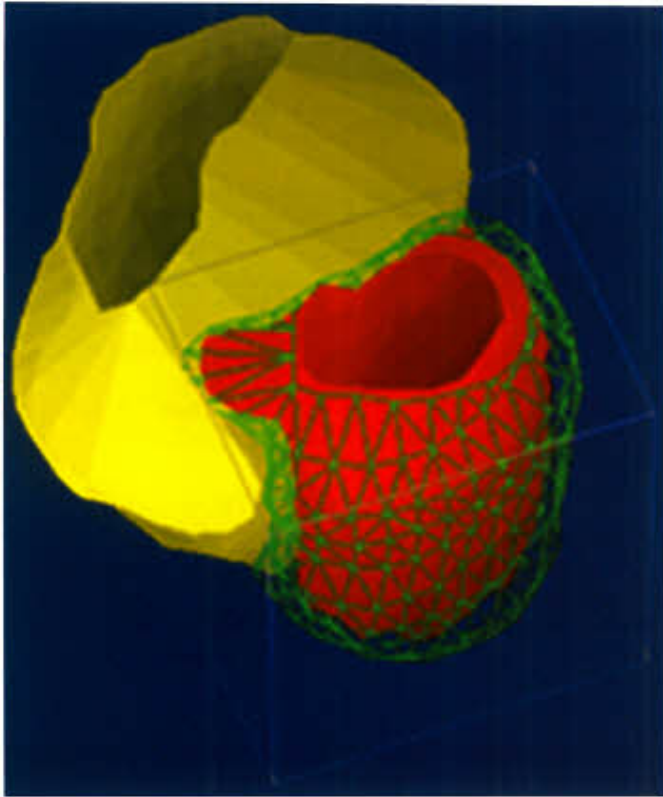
Three dimensional MRI rendered image of left and right ventricle 8 years after TOF repair. RV shaded yellow, LV shaded red. Note the size disproportion between the ventricles caused by severe RV dilatation. (Image courtesy of Dr. Shi-Joon Yoo of The Hospital for Sick Children, Toronto.)
